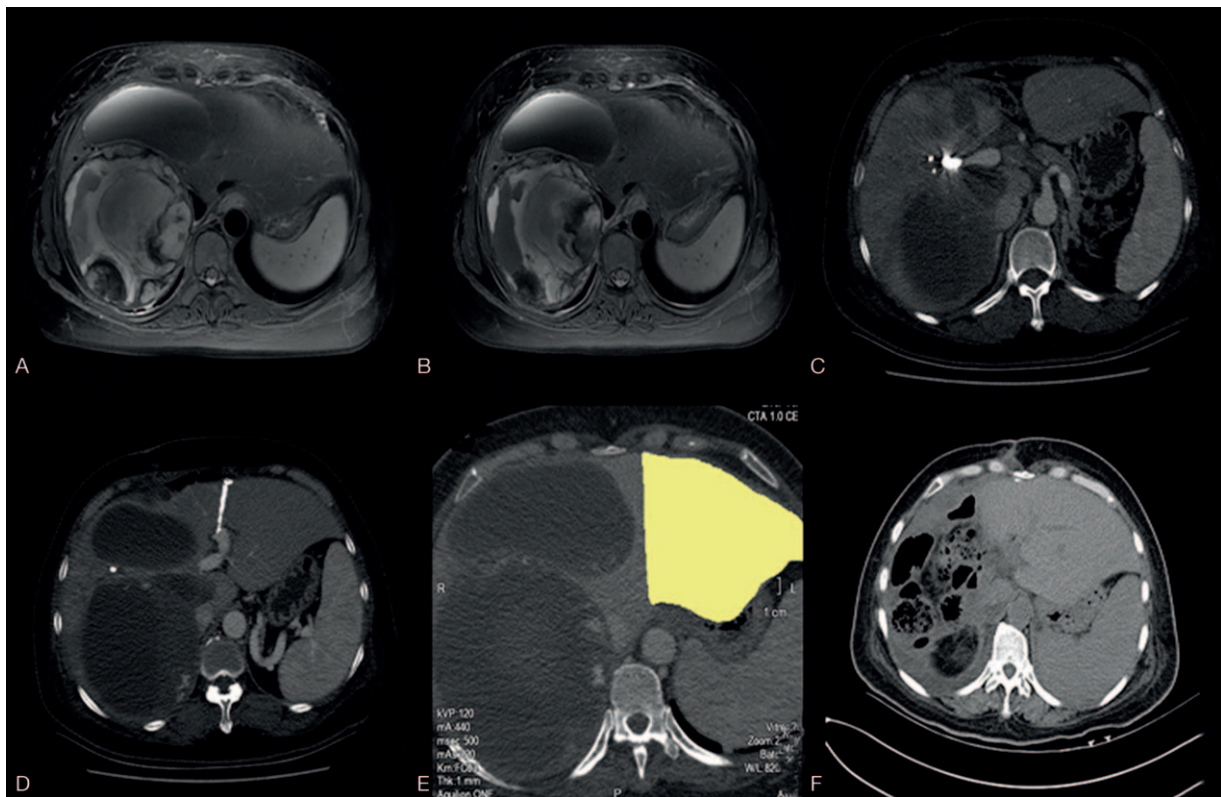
Computed tomography and magnetic resonance images of the liver. Liver metastasis was stable at the beginning of imatinib therapy (A) and 6 months later (B). Right portal vein embolization (C) combined with percutaneous microwave ablation (D) were performed as stage I before liver resection. Increased volume of the left lateral lobe (E) after stage I, and postoperative CT image (F).
